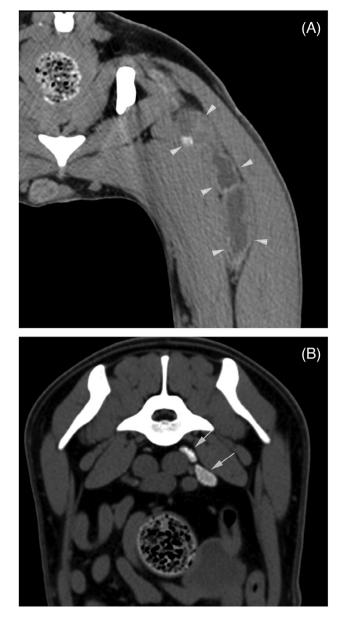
Transverse precontrast CT images with soft tissue algorithm of the pelvis and hindlimbs (A: WL 40, WW 350; B: WL 224, WW 747). A, Tubular shaped, mixed soft tissue/fluid attenuating and partially mineralized mass between biceps femoris and adductor muscles (white arrow), consistent with "pseudotumor". B, Homogenous hyperattenuation of the left medial iliac lymph nodes (white arrowheads).
